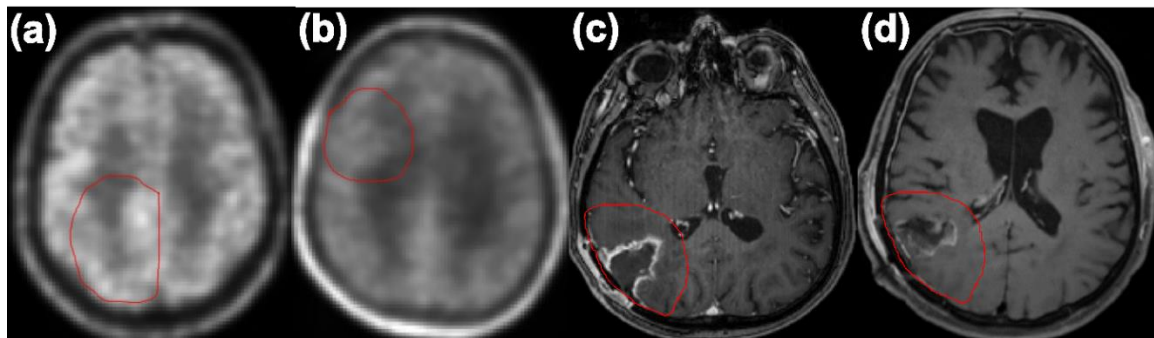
(a) Example PET image of a false-positive case. The PET image appears patchy, compared to (b) a true negative PET image with overall homogenous appearance. (c) Example T1c-w MR image of a false-positive case with confounding effects of surgically induced contrast enhancement in the second baseline MR image. The clinical decision of MR-negative status was made on early postsurgical MRI shown in (d), which does not show contrast enhancement on surgical boundaries. Red contours represent the CTV.
